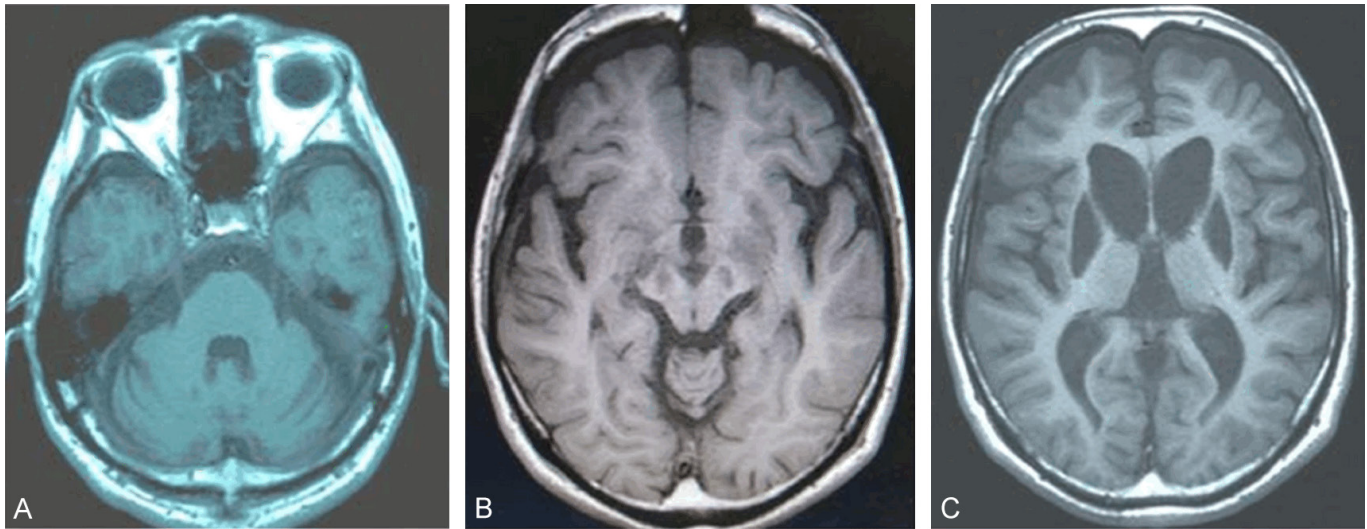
T1-weighted MRI scans of a 42-year-old Parkinson's disease (PD) patient reveal distinct neuroanatomical changes. A. A cross-sectional image at the level of the pons shows notable atrophy of the cerebellar cortex. B. A midbrain section highlights hypointense alterations within the substantia nigra. C. An image at the level of the basal ganglia demonstrates symmetrical hypointense signals within the head of the caudate nucleus and the globus pallidus. Reproduced from Ohta E, Takiyama Y. MRI findings in neuroferritinopathy. *Neurology research international*. 2012;2012(1):197438. © 2012, with permission under Creative Commons Attribution 4.0 International Public License (<https://creativecommons.org/licenses/by/4.0/legalcode>) [6].
